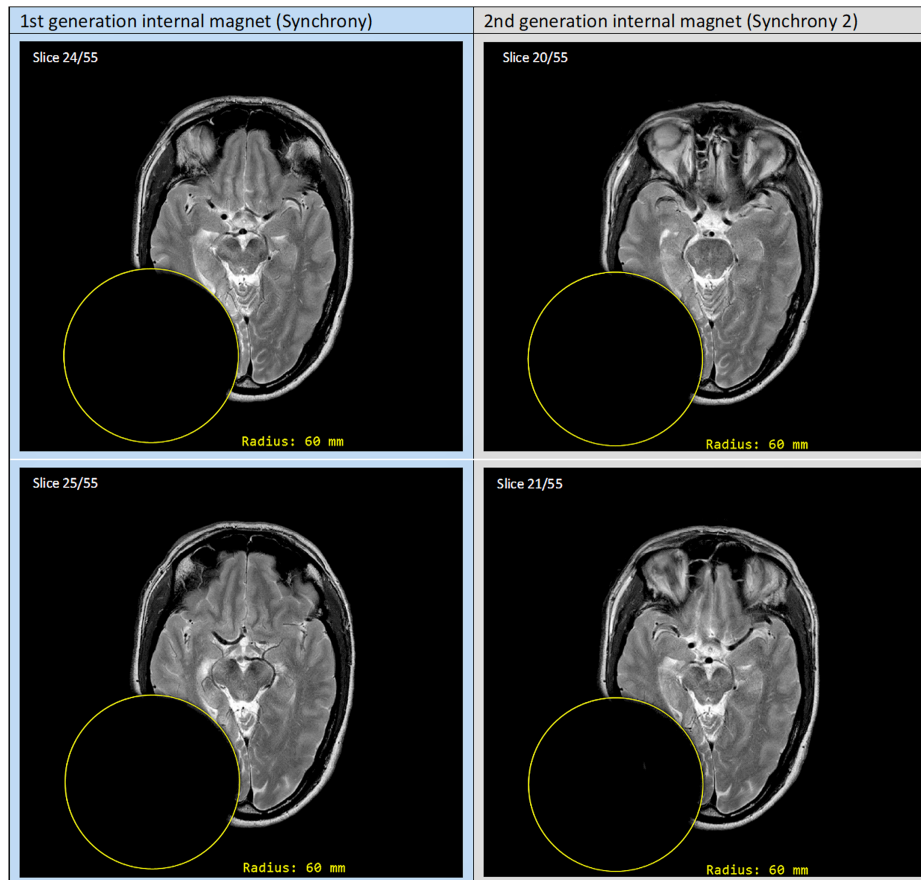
Comparison of the maximum artifact size of the first- and second-generation diametrical internal magnet study: Both 3T MRI T2W TSE image artifacts extend over a circular area with the same radius of 60 mm.
